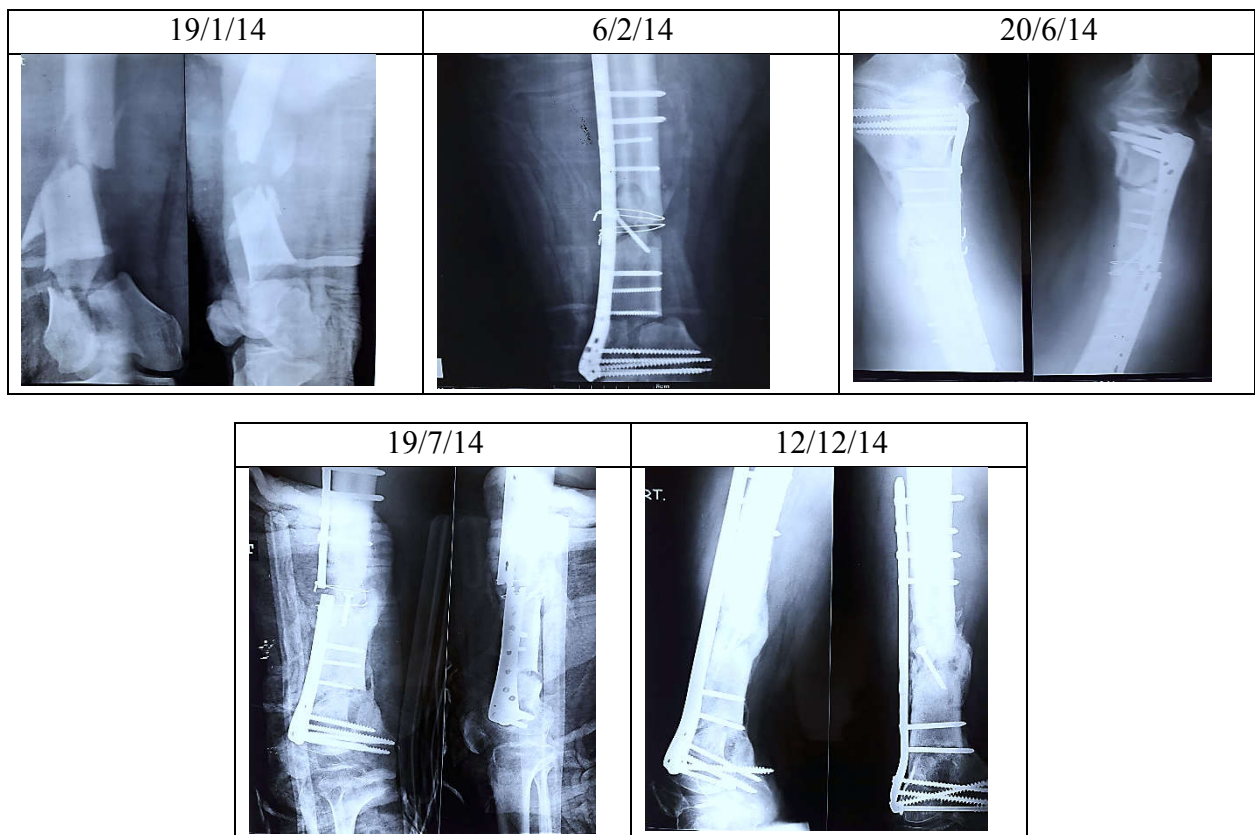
X-ray distal end of right femur antero-posterior & lateral view of case 4
